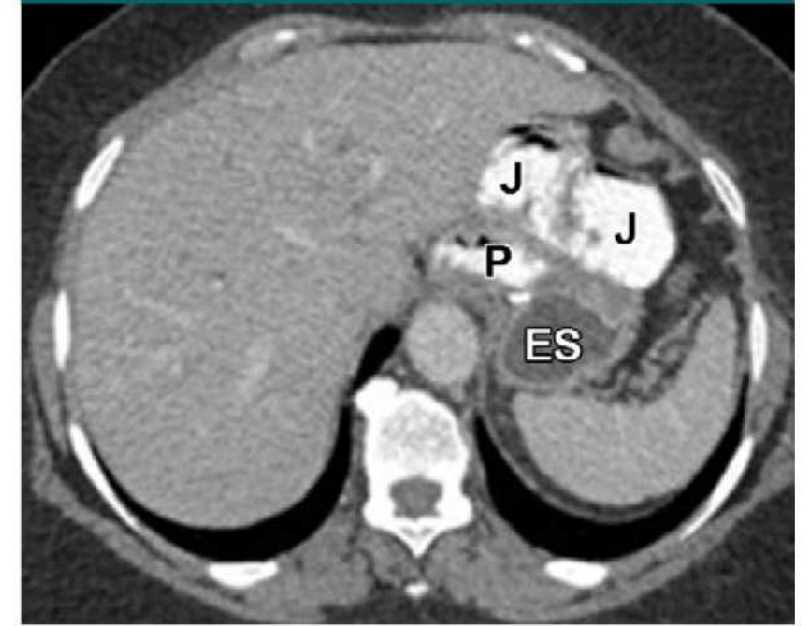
Normal appearance of Roux-en-Y gastric bypass at CT. Axial CT image after oral and intravenous contrast material administration shows small gastric pouch (*P*) separated by staple line from excluded stomach (*ES*) laterally. Jejunal Roux limb (*J*) is anastomosed to gastric pouch anteriorly. Note oral contrast material opacifying pouch and Roux limb, whereas excluded stomach is not opacified.
